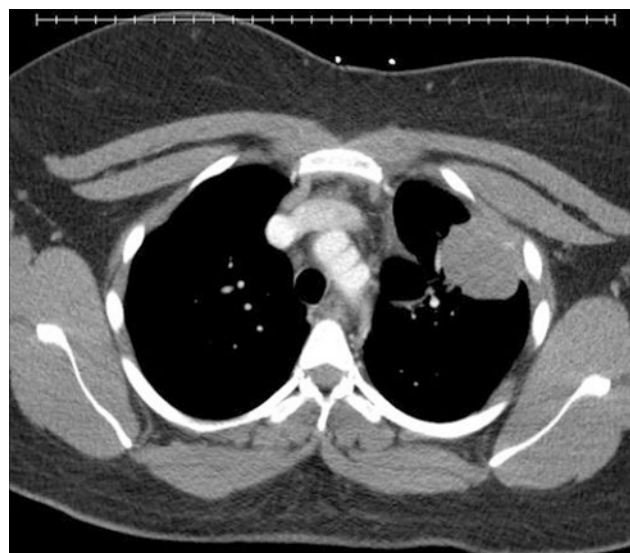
CT scan showed a large pleural-based mass in the left upper lobe
